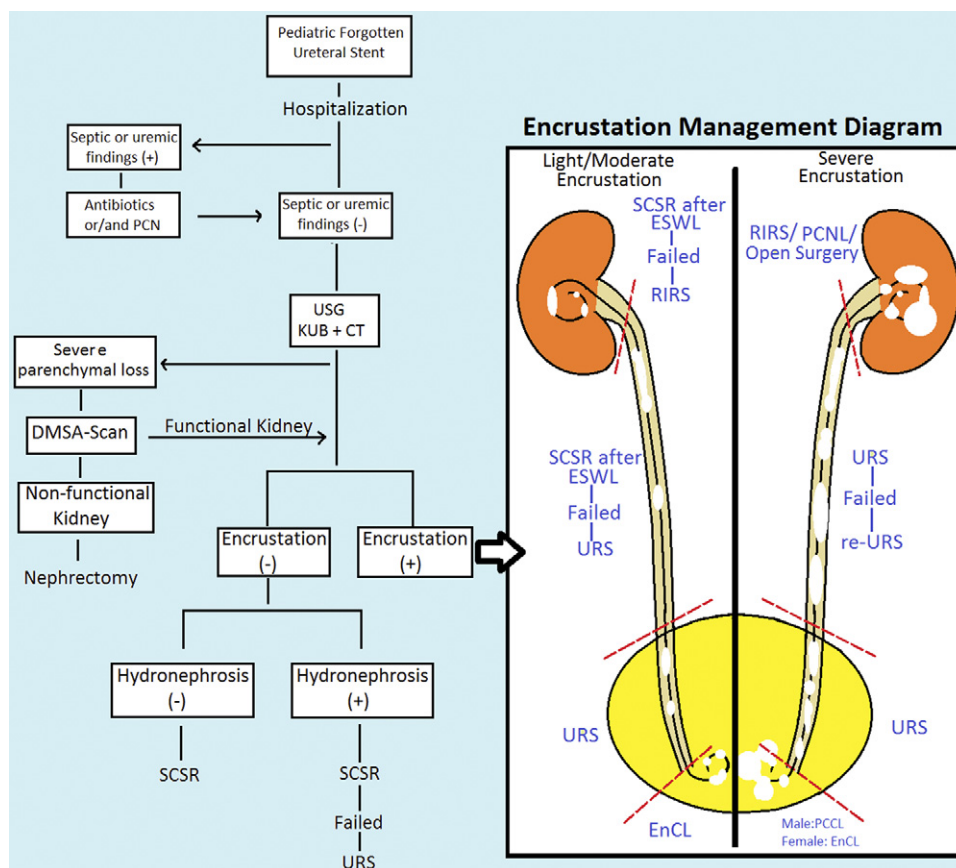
Algorithm for management of pediatric FUS. *DMSA*, dimercapto-succinic acid. *ESWL*, extracorporeal shock wave lithotripsy. *USG*, ultrasonography.
